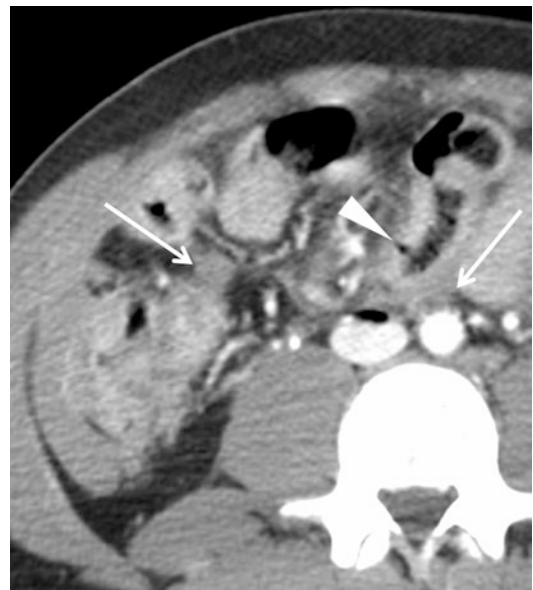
Axial CT contrast-enhanced scan shows foci of intramural air (*arrowhead*) in a thick-walled small bowel loop. Interloop fluid is also seen (*thin arrows*)
